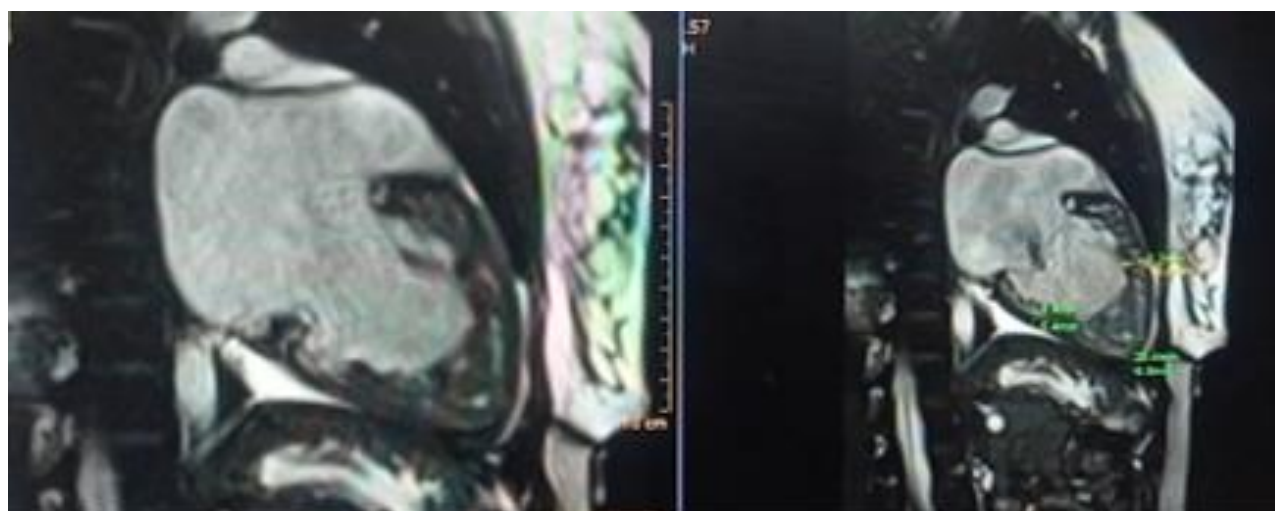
Cardiac MRI- A two chamber bright blood images with Prominent apex and anterior wall.
